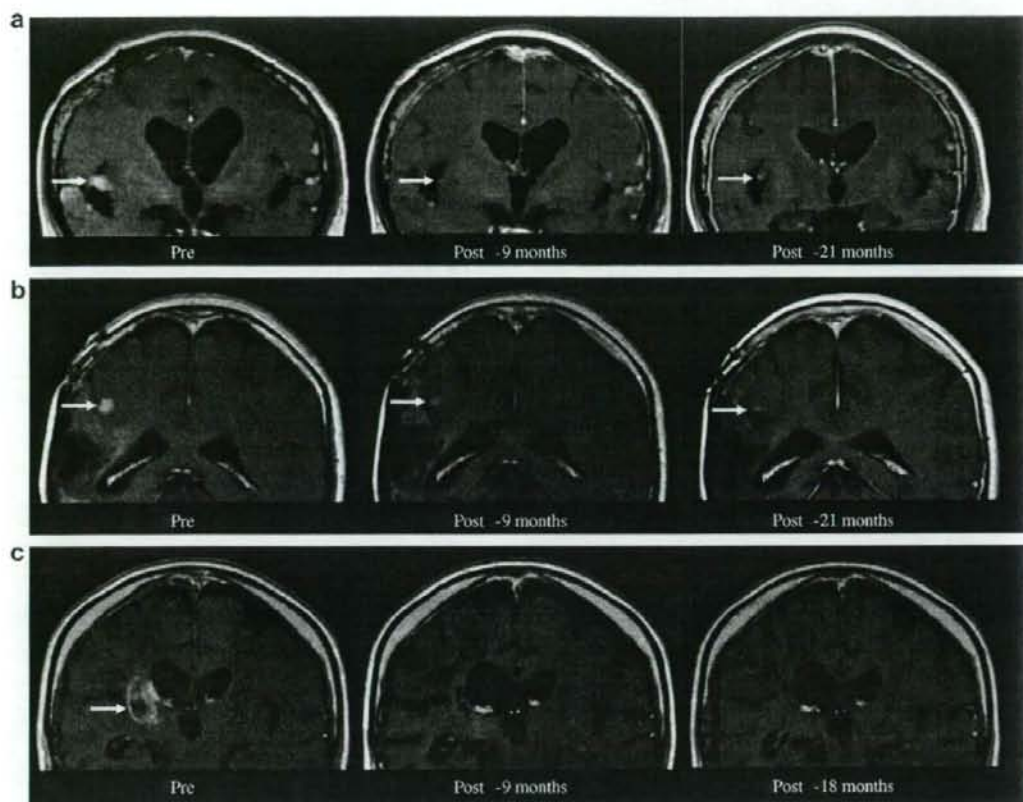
Clinical tumour response. Partial tumour responses were observed in patient #1 with pinealoblastoma (a) and patient #2 with glioblastoma (b), whereas a complete tumour response was observed in patient #3 with anaplastic oligodendroglioma (c). Representative gadolinium contrasted magnetic resonance imaging scans taken before vaccination (Pre), after 9 months of vaccination (Post-9 months), and after an extended vaccination period (Post-21 months and Post-18 months) are shown. Main target lesions are indicated by arrows.
